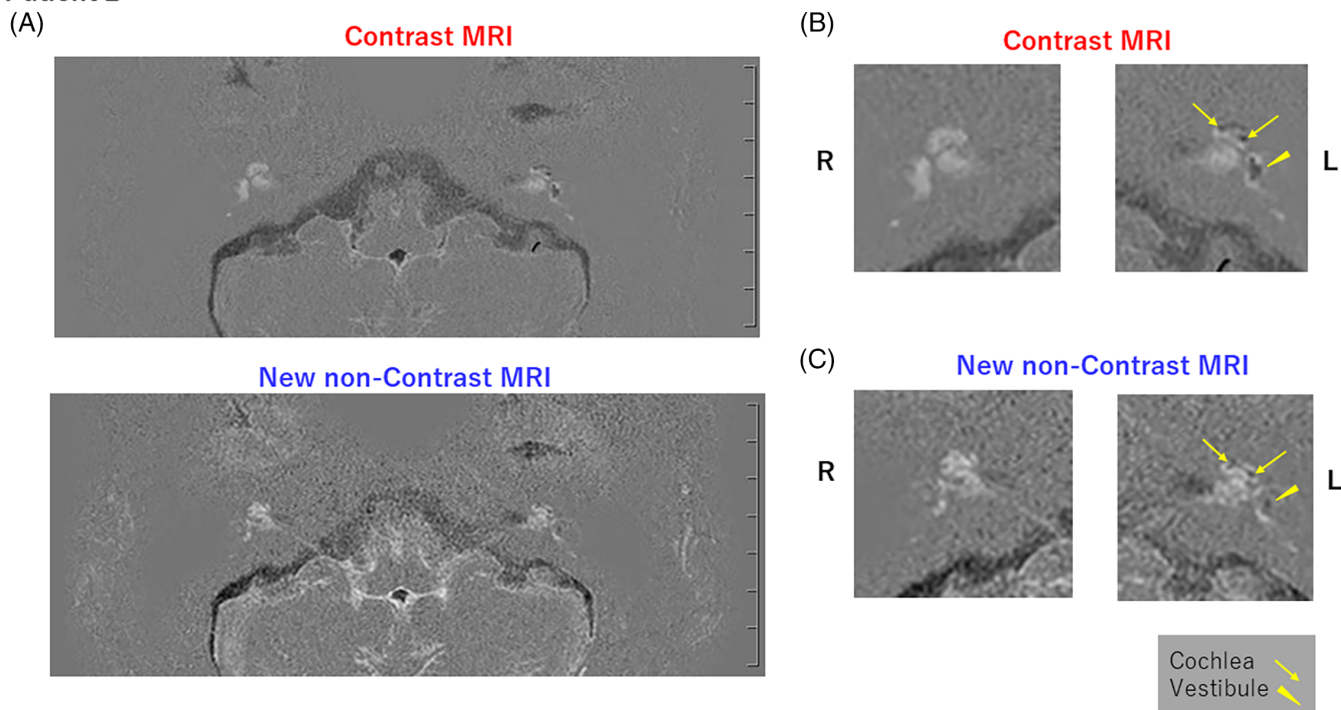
Images comparing contrast and new non-contrast MRI of Patient 2. Patient 2 was a 25-year-old man with Stage 4 left-sided Ménière's disease. (A) Images of the inner ear at the cerebellopontine angle: The upper row is contrast MRI and the lower row is new non-contrast MRI. (B) Magnified images of the inner ears by contrast MRI. (C) Magnified images of the inner ears by new non-contrast MRI. Lesions with decreased signal intensity are apparent in the new non-contrast MRI; they are consistent with images considered to represent endolymphatic hydrops in the left vestibule and cochlea.
